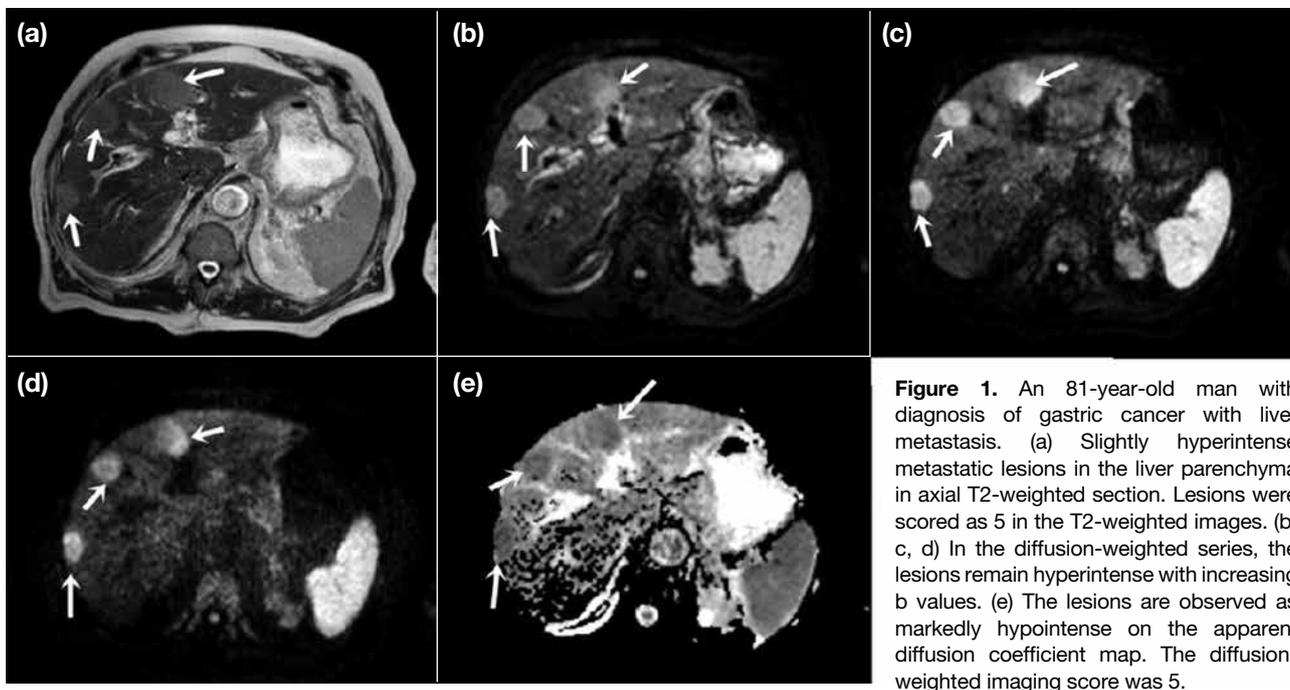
An 81-year-old man with diagnosis of gastric cancer with liver metastasis. (a) Slightly hyperintense metastatic lesions in the liver parenchyma in axial T2-weighted section. Lesions were scored as 5 in the T2-weighted images. (b, c, d) In the diffusion-weighted series, the lesions remain hyperintense with increasing b values. (e) The lesions are observed as markedly hypointense on the apparent diffusion coefficient map. The diffusion-weighted imaging score was 5.
